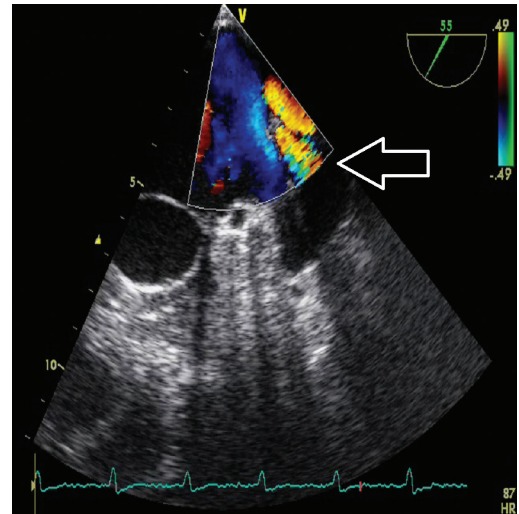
Transesophageal echocardiography, mid esophageal view 55°. Accessory structure between left atrial appendage and left upper pulmonary vein.
